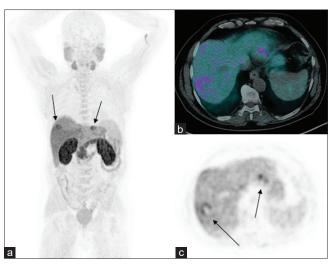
Maximum intensity projection shows two areas of focal [18F] F-Choline uptake within the right and left hepatic lobes (indicated by arrows) (a) Transaxial fused positron emission tomography (PET)—computed tomography (b) and emissive PET (c) images show two rings of elevated tracer uptake at the VII and II liver segments (diameter of 3 cm and 2.8 cm, respectively), surrounding a core of low metabolism
